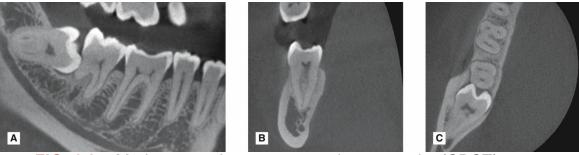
Modern cone beam computed tomography (CBCT) radiographic images in three dimensions of the lower right molar teeth in the (A) sagittal, (B) coronal and (C) axial planes.
